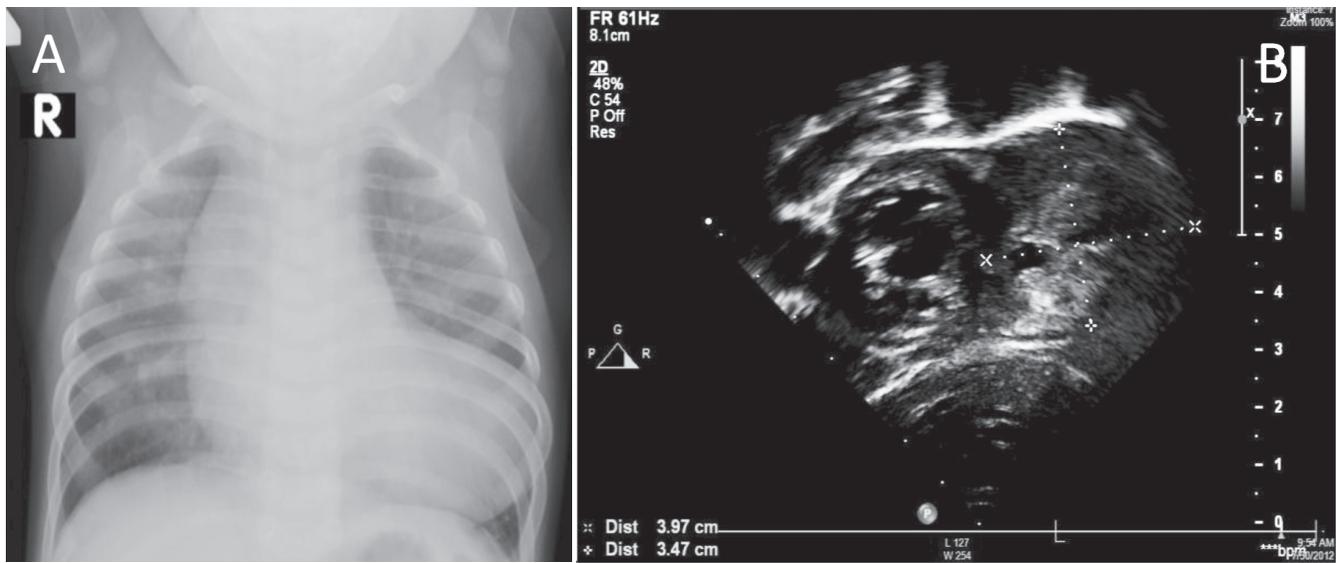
A) Chest X-ray of a 7-month-old infant shows abnormal bulging of left cardiac border. B) Transthoracic echocardiogram of the same patient demonstrates a 3.9x3.4 cm aneurysm protruding from left ventricle.
